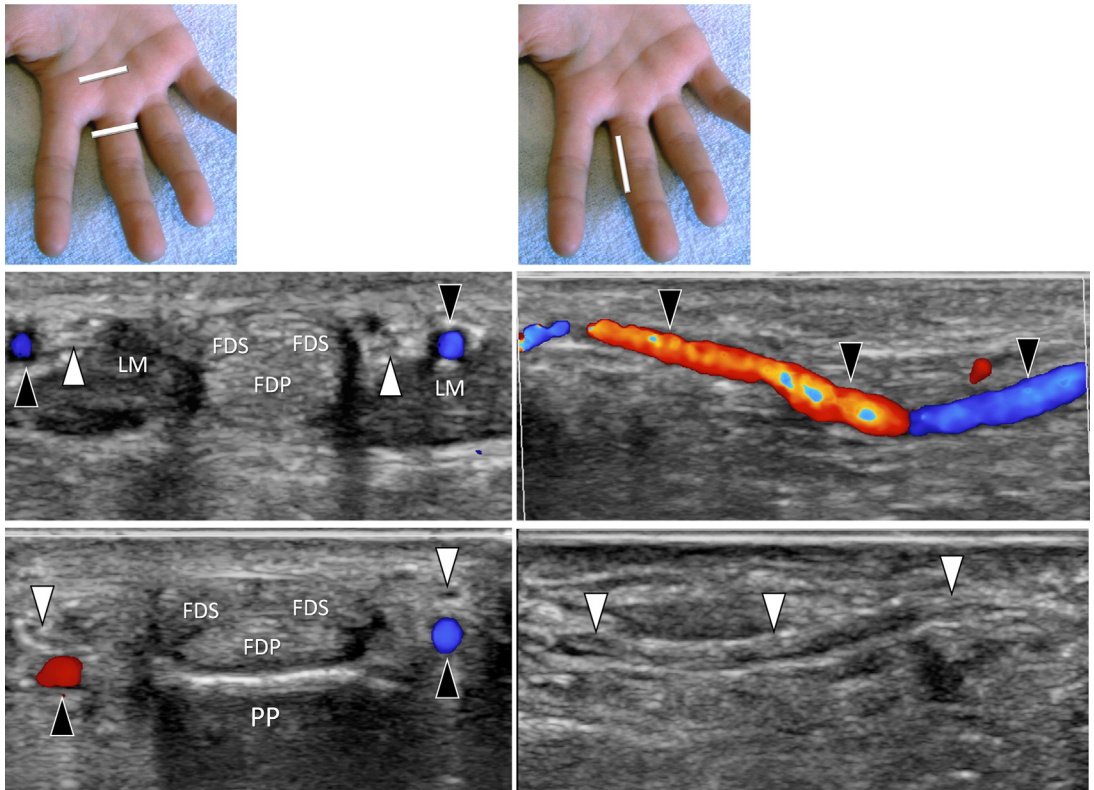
Digital arteries and nerves run alongside the FDS and FDP tendons, close to the lumbrical muscles. Arteries, usually smaller than the adjacent veins, are better identified with color Doppler US (*black arrowheads*). Nerves (*white arrowheads*) are recognizable by their fascicular appearance. LM, lumbrical muscle.
